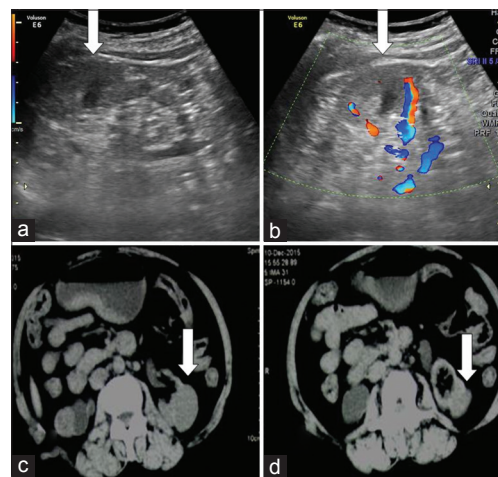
Gray scale ultrasound (a) shows an isoechoic area in mid pole of shrunken left kidney and Doppler (b) shows multiple vessels in the same region. Computed tomography (c and d) shows isoechoic exophytic soft tissue density lesion (white arrows) in the mid pole of left kidney
